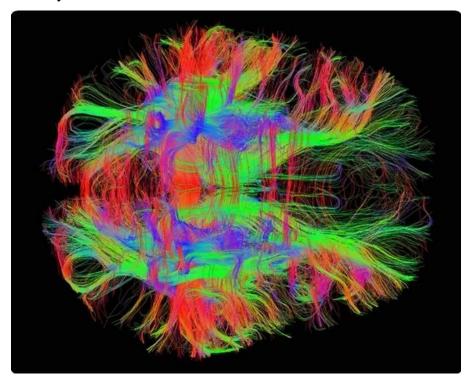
From Palombo M. et al "SANDI: A compartment-based model for non-invasive apparent soma and neurite imaging by diffusion MRI" ¹³⁹
